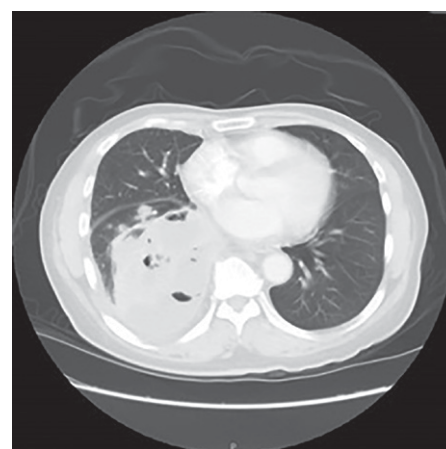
CT scan of the chest showing resolving right pleural effusion with R.L.L. infiltrate.
